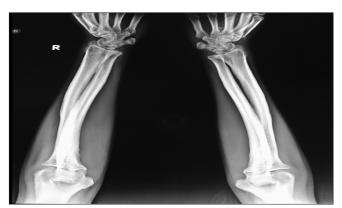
Radiograph of both forearms AP view shows linear periosteal reaction
